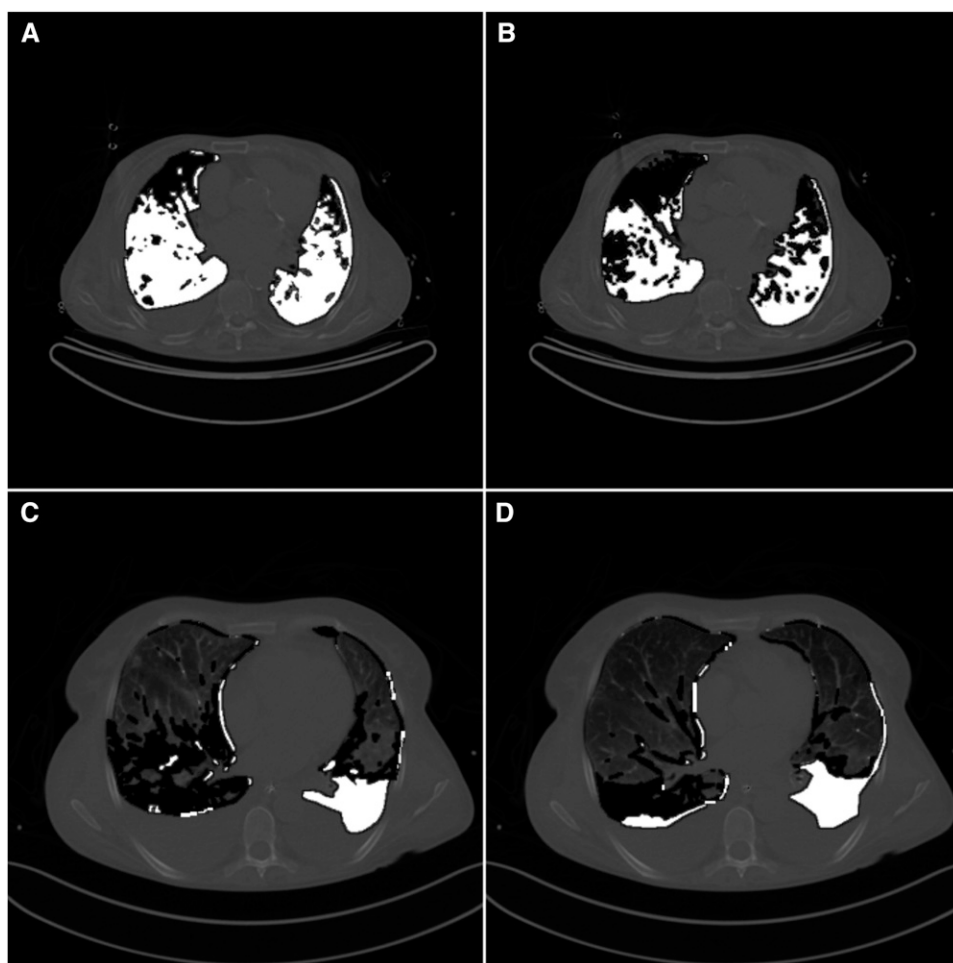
Examples of computed tomography (CT) scan images taken at 5 cm H_2O positive end-expiratory pressure (PEEP) (A and C) and at 15 cm H_2O PEEP (B and D). *White*, nonaerated tissue; *black*, poorly aerated tissue. A and B are from the CT scan of a patient with severe acute respiratory distress syndrome ($Pa_{O_2}/F_{I_{O_2}}$ at 5 cm H_2O PEEP 86.5 , first tertile); CT scan-based recruitment measured by not-inflated tissue only amounted to 245 g, whereas when adding poorly aerated tissue, it decreased to 86 g because of the 159 g increase of poorly aerated tissue from 5 to 15 cm H_2O PEEP. C and D are from the CT scan of a patient with mild acute respiratory distress syndrome ($Pa_{O_2}/F_{I_{O_2}}$ at 5 cm H_2O PEEP 272.5 , third tertile); CT scan-based recruitment measured by not-inflated tissue only amounted to -18 g, whereas when adding poorly aerated tissue, it increased to 98 g because of the 116 g decrease of poorly aerated tissue from 5 to 15 cm H_2O PEEP.
